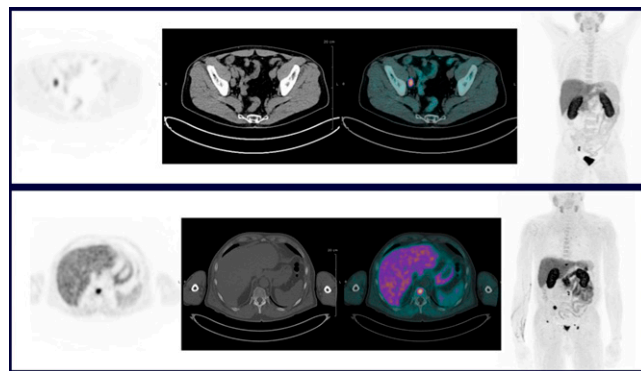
^{18}F -choline PET/CT in biochemical recurrent prostate cancer. Example images highlight nodal uptake reflecting a metastatic focus (top panel), and an osseous metastasis to a vertebral body with a high degree of uptake (lower panel). The level of uptake contributes to a combined score reflecting the likelihood of progression free survival.
